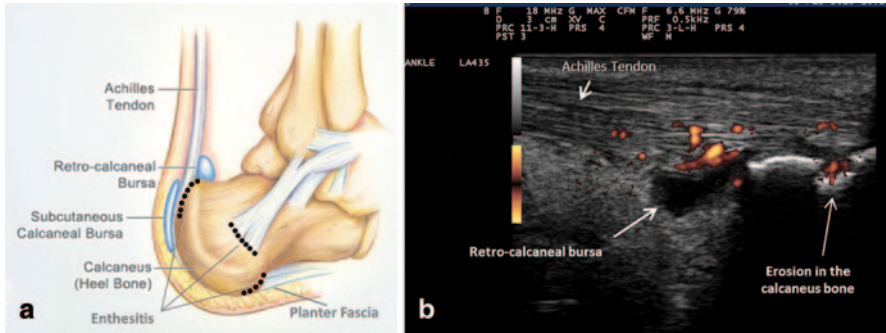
a Picture of ankle depicting the distinct areas of synovio-entheseal complex. b Enthesis organ, composed of the ligament insertion points into bone, the adjacent synovium and bursa as well as the underlying bone, detected by ultrasound (US) examination in b mode combined with power Doppler in ankylosing spondylitis patient. Abnormal vascularization associated with marked swelling and decreased echogenicity of the enthesis at the cortical junction can be seen, as well as erosion of the calcaneus bone. Tendon thickness at the level of the enthesis is 7.2 mm and is associated with a retro-calcaneal bursa with enhanced vascularity
